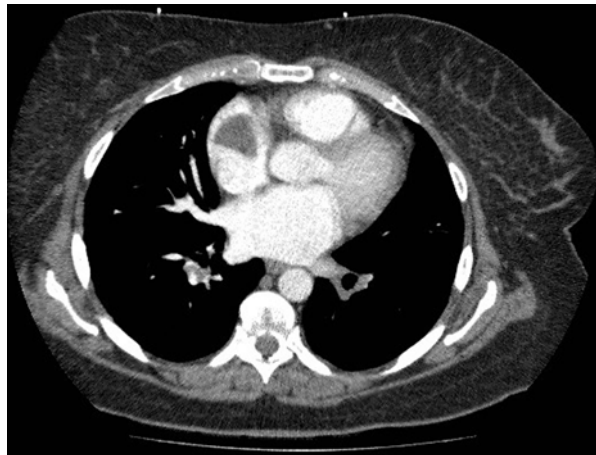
Pulmonary emboli in the right lower lobe pulmonary arteries with right atrial thrombus demonstrated on computed tomography pulmonary angiogram (CTPA)
